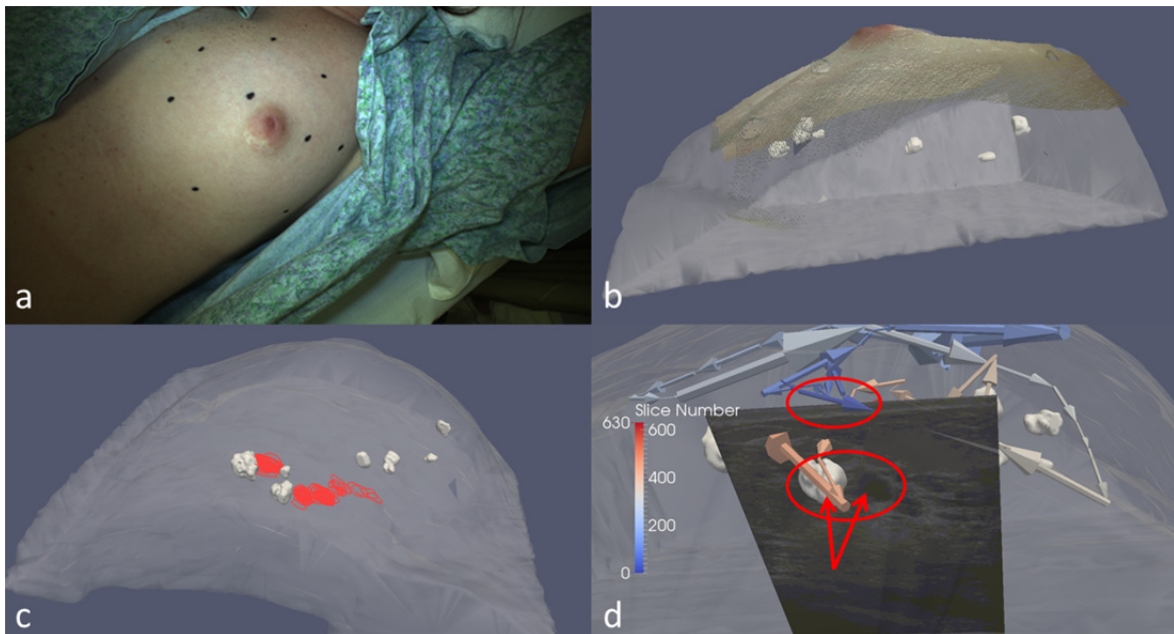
An example of tracked ultrasound data acquired during a breast examination of a patient with benign cysts (a), showing the registration of LRS cloud to MR surface (b). The swabbed ultrasound cyst contours are spread over a wide volume due to dragging of the tissue (c), which was confirmed in the probe tracking vector history (d).
